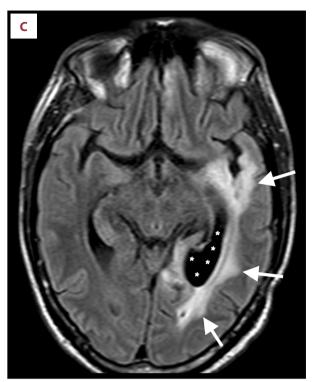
Imaging studies. (A) FLAIR images at presentation. Note circumscribed heterogenous 4-cm mass-like lesion in the left occipital lobe (arrows). Note also a 15-mm lesion with similar single characteristics within the medial right frontal lobe (arrow). Further areas of edema are present in the splenium of the corpus callosum and temporal lobe on the left, which correlate with the patient's alexia without agraphia and right superior quadrantanopia, respectively. FLAIR images are shown. T1, T2, diffusion, and contrast-enhanced imaging modes revealed partial restricted diffusion and enhancement, but these abnormalities are more marked on FLAIR images. (B) FLAIR images following biopsy. Ten days later, there was significant deterioration with extension of the edema into the left temporal lobe and a mild mass effect (arrows). A more circumscribed focus of high signal intensity within the center of the lesion represents hematoma following biopsy. The right frontal lesion is unchanged. (C) FLAIR images at day 140. Follow-up scan 5 months later demonstrates resolution of the edema on the left, with significant dilatation of the posterior horn of the left lateral ventricle, consistent with ex-vacuo dilatation (asterisks). The high signal intensity within the left temporal lobe, which continues around the dilated posterior horn, is well-demarcated and is consistent with gliosis (arrows).
